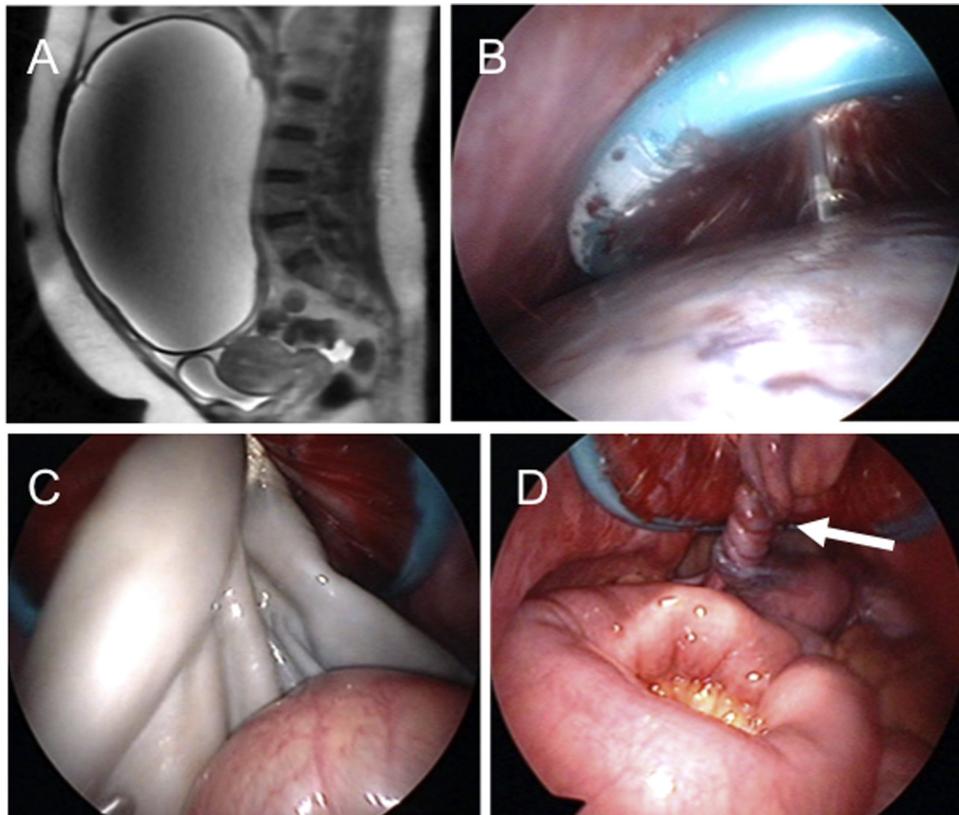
Gasless multi-port laparoscopic left salpingo-oophorectomy for a large ovarian tumor in a 44-year-old multipara woman with chronic adnexal torsion. The patient's history included one cesarean section. The patient was referred by a private physician due to the presence of a palpable abdominal mass at 11 days after the onset of abdominal pain and vomiting, which subsequently subsided spontaneously. At the examination, the patient had no apparent abdominal symptoms requiring emergent intervention, and elective surgery was performed on the 28th day after the onset of symptoms. (A) Sagittal T2-weighted magnetic resonance imaging revealed a large multi-cystic mass measuring 26 cm in diameter. (B) A cystic tumor was punctured through a supra-pubic working port and the contents of the cyst were aspirated. (C) The tumor was gradually exteriorized. (D) After the identification of a torted pedicle composed of utero-ovarian and infundibulopelvic ligaments (arrow), salpingo-oophorectomy was performed. The precise pathological diagnosis of the excised tumor was difficult due to the severe hemorrhagic necrosis of the cystic tumor wall. The epithelial cells lining the tumor wall were observed to be falling off.
